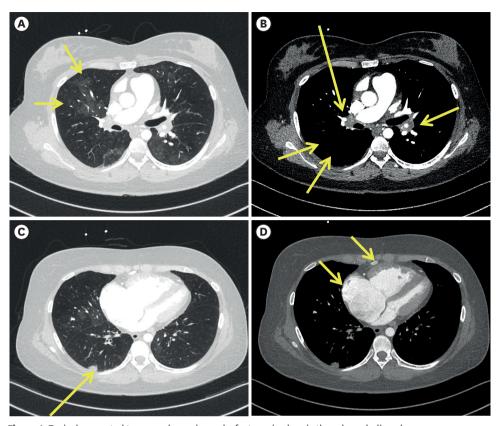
Typical computed tomography angiography features in chronic thromboembolic pulmonary hypertension patients. (A) Mosaic pattern of lung parenchyma; (B) Reduced visibility of distal vessels, calcified thrombi, and chronic thrombi; (C) Lung infarction; (D) Enlargement of the right atrium and ventricle, deviation of left ventricular septum.
